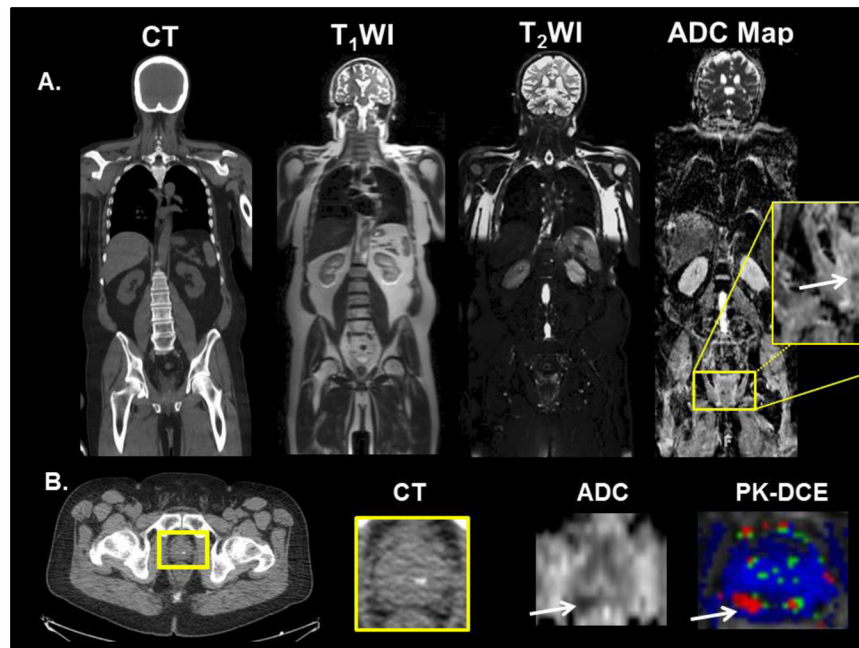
Example of WB-MRI screening in 60-year-old man with a stage T2B, Gleason 9 with increasing PSA, post external beam radiation and androgen deprivation therapy. A. CT and whole-body MRI was performed for interrogation of metastatic disease. Potential recurrence was only found in the right peripheral zone on the WB-ADC map and shown in the yellow box. B. Localized MRI with DWI/ADC and Pharmacokinetic-DCE (PK-DCE) was performed “*on the fly*” for confirmation of prostate cancer recurrence.
